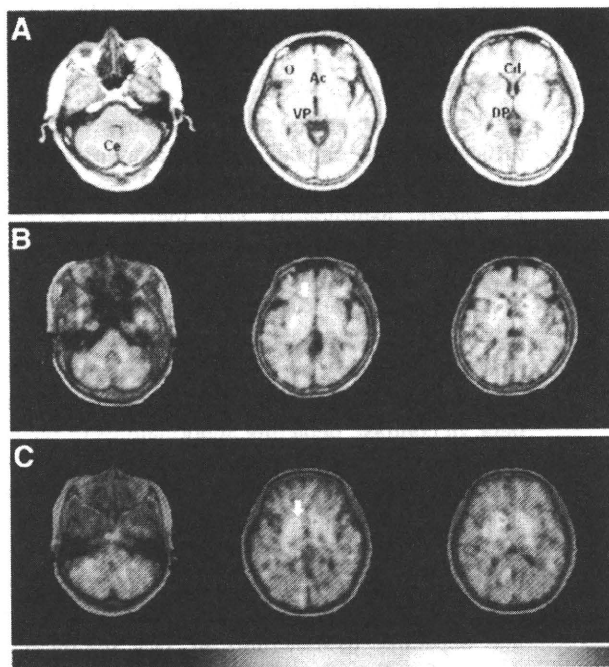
^{11}C -CFT PET images and ROI setting. (A) Irregular ROIs, drawn bilaterally on concerned regions on MR images, were placed on corresponding PET images. (B) PD patient with longer conversion period from HY stage 1 to HY stage 2. (C) PD patient with shorter conversion period from HY stage 1 to HY stage 2. Arrow indicates reduction in ^{11}C -CFT binding in nucleus accumbens. Color bar indicates quantified level of RI (from 0 to 3). Ac = nucleus accumbens; Cd = caudate; Ce = cerebellum; DP = dorsal putamen; O = orbitofrontal cortex; VP = ventral putamen.
